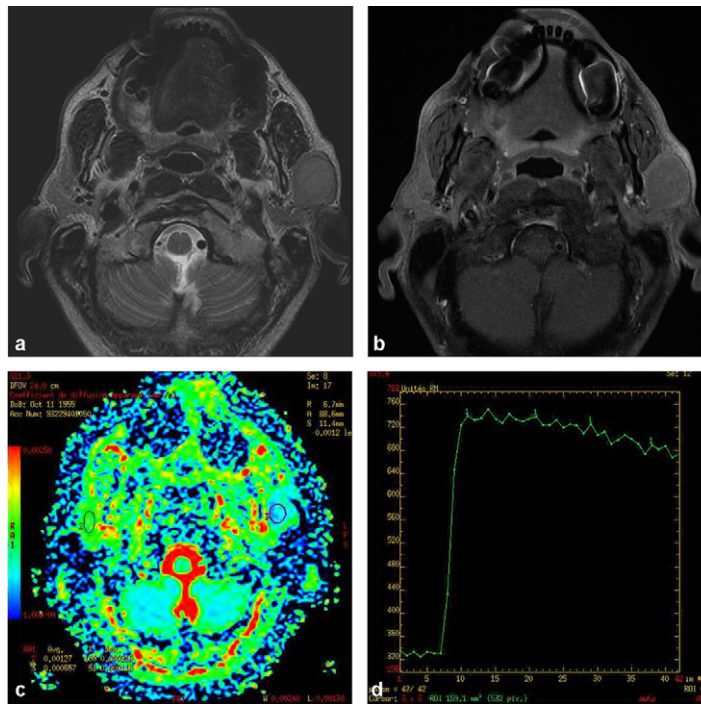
High-grade tumor. 3 cm tissular formation of the superficial left parotid lobe: a: T2-weighted axial slice: lesion in isosignal on T2-weighted image; b: T1-weighted gadolinium-enhanced fat-sat axial slice: moderate uptake; c: apparent diffusion coefficient map: $ADCr = 0.5$; d: perfusion curve showing descending plateau with wash-out less than 30%.
